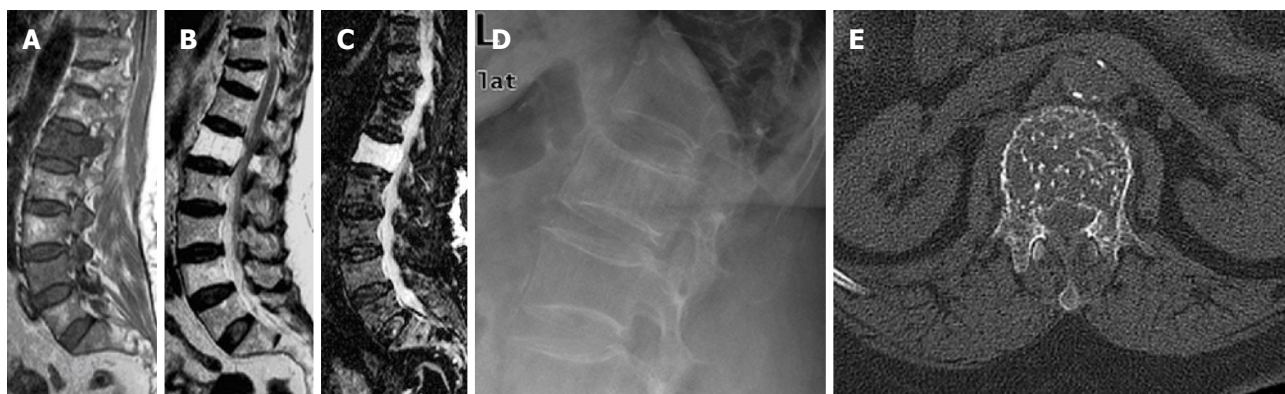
Sagittal T1W (A), T2W (B) and STIR (C) images of 65-year-old female showing L1 vertebral body atypical hemangioma with diffuse low signal intensity on T1W image and high-signal intensity on T2W and STIR images presented on a background of lumbar spondylotic changes. Note also, DV11 old porotic wedging. Companion imaging showed prominent trabecular pattern on focused radiography (D) and CT (E) of the LV1 with characteristic polka-dot sign. STIR: Short tau inversion recovery.
